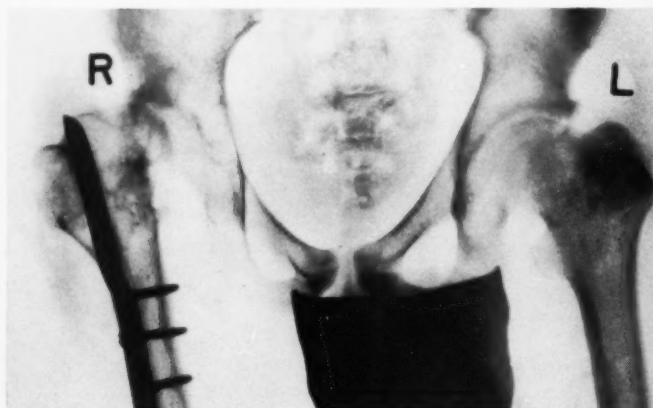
Roentgenogram of the same patient as in Figure 14, at age 15 years, two years after McMurray osteotomy. Note 1) in comparing this roentgenogram with Figure 14 there is a very definite increase in the subluxation of the right hip with an adduction deformity, and 2) the right acetabulum is extremely shallow as compared with that on the left.
